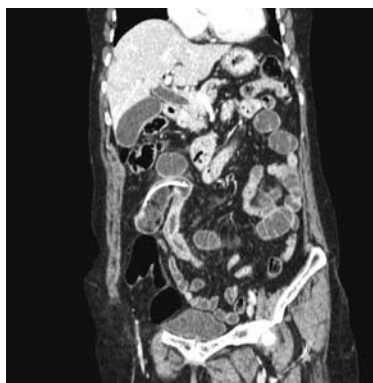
The coronal MIP abdominal CT views show the stent in the ileum lumen indenting the ileum wall; proximal to this level, the intestinal segments are dilated.
